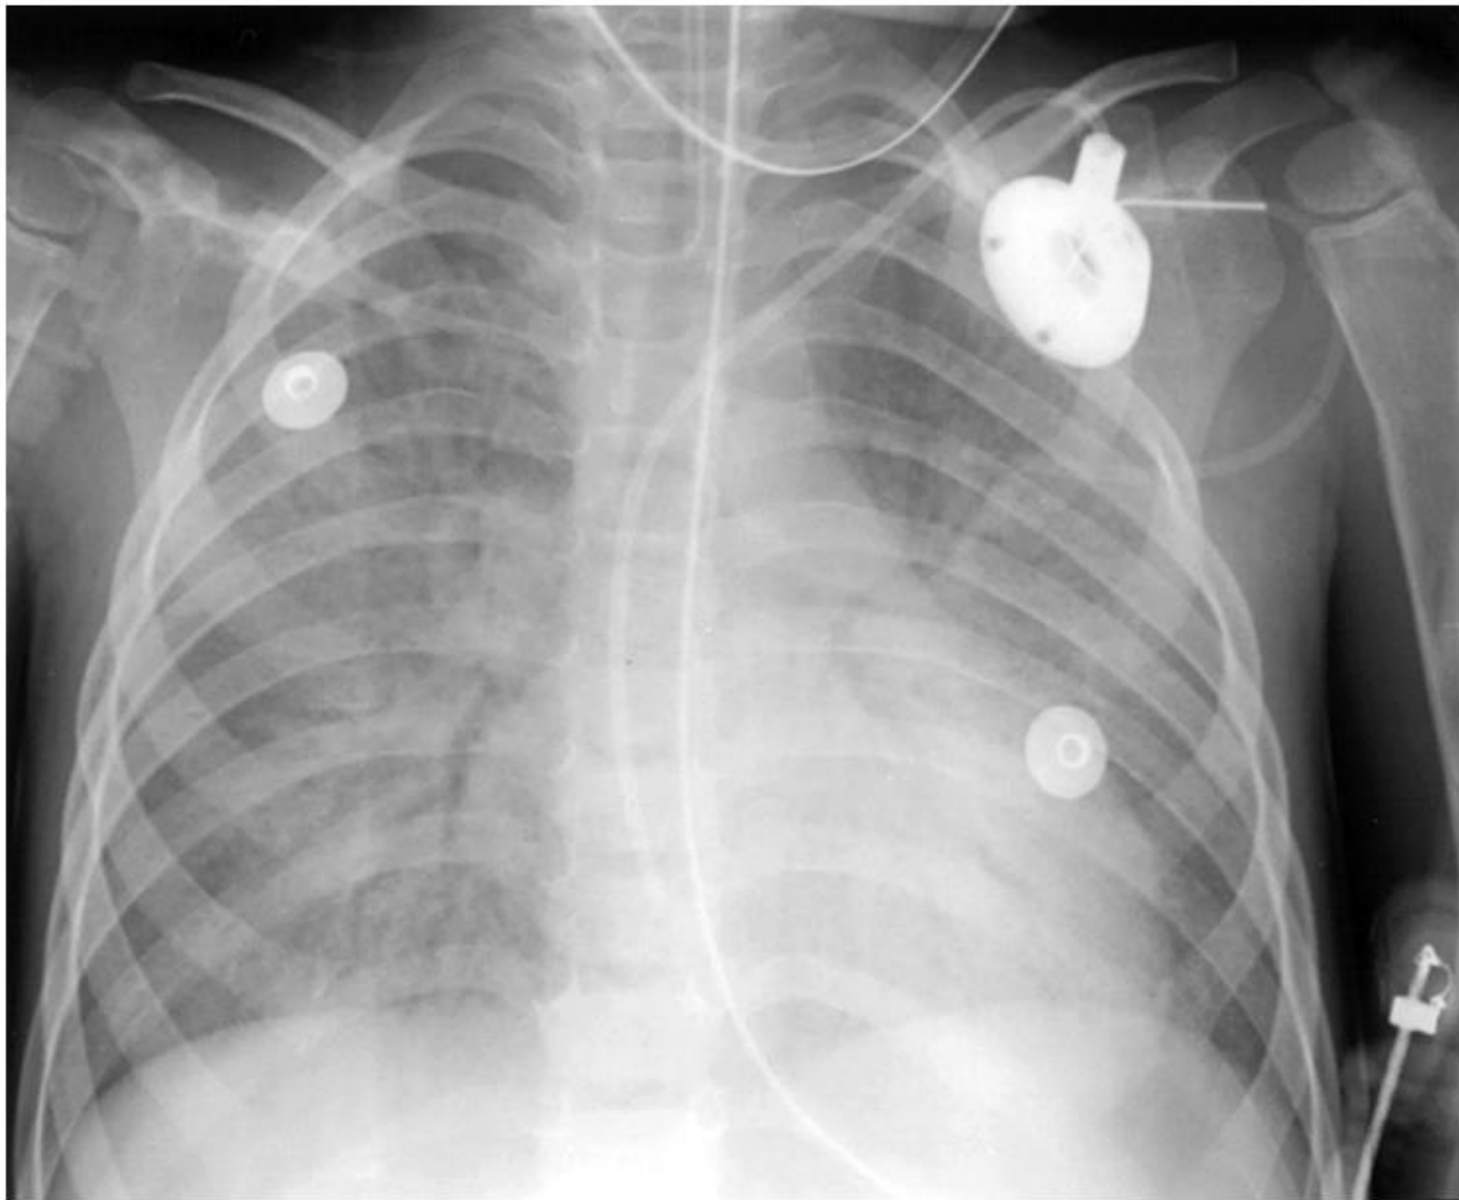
Chest radiograph of a patient with ARDS. Note the infiltrates in all five lobes, the air bronchograms that appear as a result of areas of consolidation, and the loss of lung volume.
